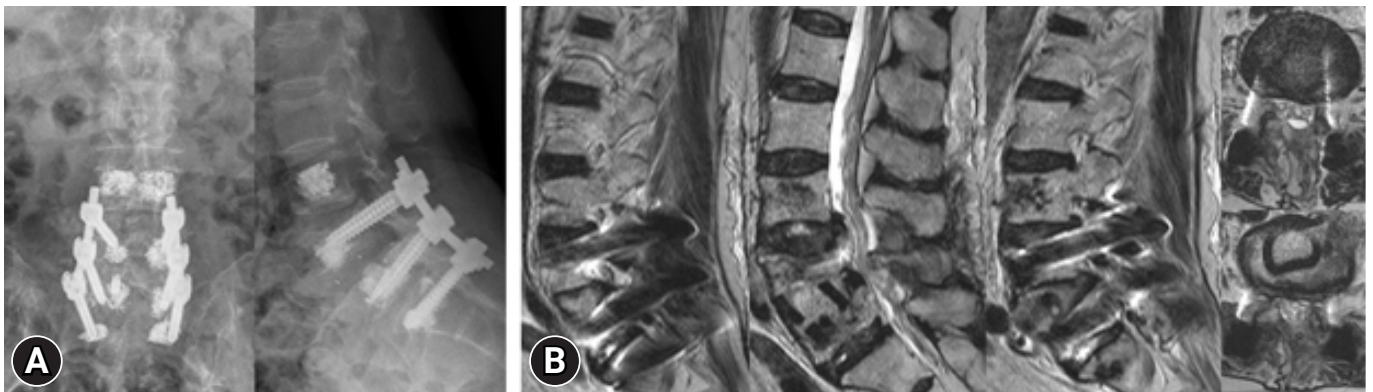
Preoperative images on X-rays, magnetic resonance imaging (MRI), computed tomography (CT), and magnetic resonance (MR) myelography. (A) X-rays (circle: instability). (B) Sagittal and axial MRI. (C) Sagittal and axial CT images. (D) An image on MR myelography.
